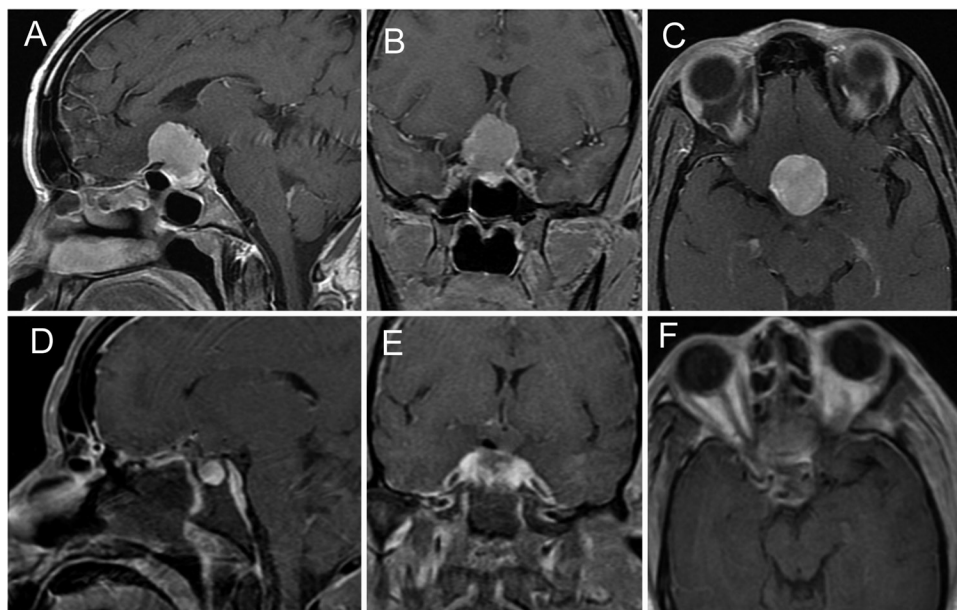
Case 2. A–C: Preoperative T1-weighted post-Gd sagittal (A), coronal (B), and axial (C) MR images demonstrating a tuberculum sellae meningioma with suprasellar extension. Hyperostosis of the tuberculum sellae is seen on the sagittal view (A). Complete Simpson Grade I resection including underlying hyperostotic bone was performed using the endoscopic endonasal extended transsphenoidal approach. D–F: Postoperative T1-weighted post-Gd sagittal (D), coronal (E), and axial (F) MR images showing gross-total resection of the tumor. The patient experienced transient neurological worsening from lumbar drain–induced intracranial hypotension. Note the interval enlargement of the pituitary gland (D), venous engorgement of the bilateral cavernous sinuses (E), and the pachymeningeal enhancement and thickening of the retroclival dura that is characteristic of intracranial hypotension. The patient returned to her neurological baseline after clamping and removal of the lumbar drain.
